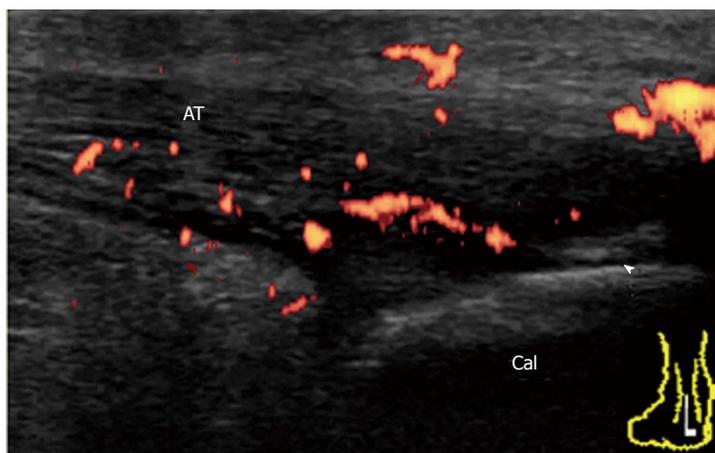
Achilles tendon enthesitis in chronic active psoriatic arthritis. Longitudinal power Doppler sonogram of AT shows increased thickness, hypoechoogenicity, and loss of fibrillar pattern of AT with intratendinous hyperemia adjacent to the enthesis insertion into the calcaneal bone. Calcification (arrowhead) is also depicted. Cal: Calcaneus; AT: Achilles tendon.
